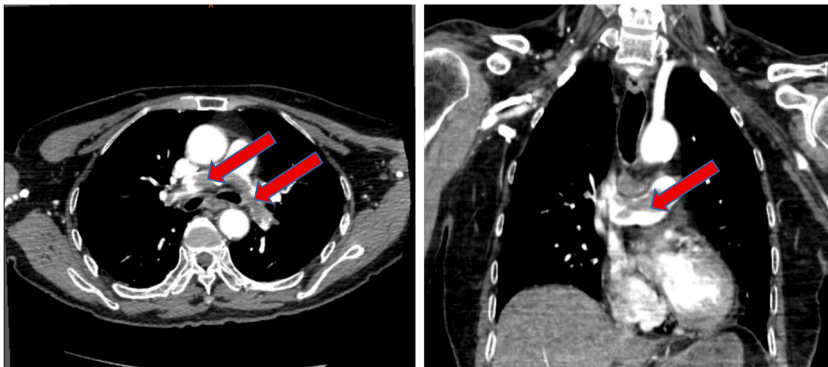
On the day of admission, enhanced CT showed bilateral pulmonary artery trunk embolization.
